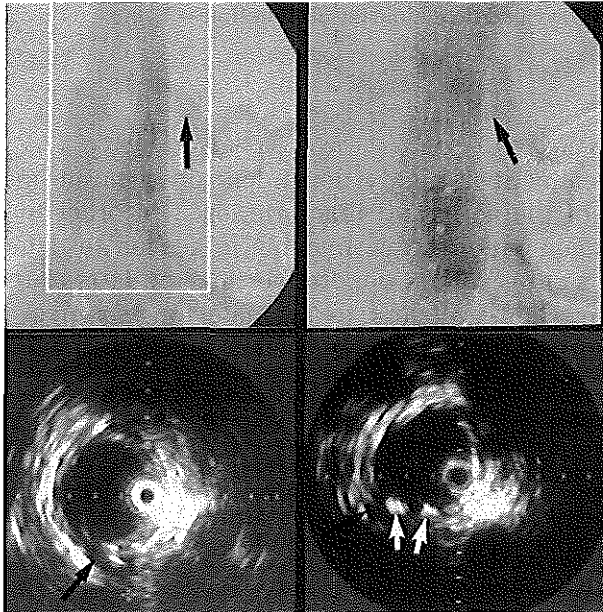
Intraoperative angiograms and intravascular ultrasound cross-sections from a renal artery obtained before and after placement of an Ancure stent-graft. On ultrasound the renal artery orifice (black arrow) is seen covered by bare stent-struts (white arrows). The angiogram revealed no diminished filling. Calibration = 5 mm.
